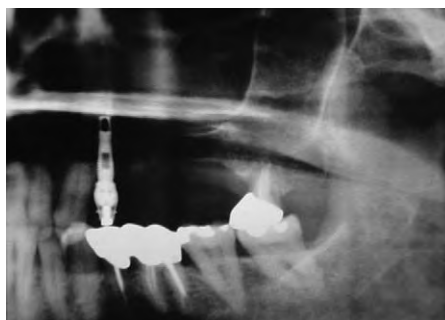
Example of clinical uses of tibia bone graft. Preoperative radiograph of area planned for a sinus lift and dental implant placement.
